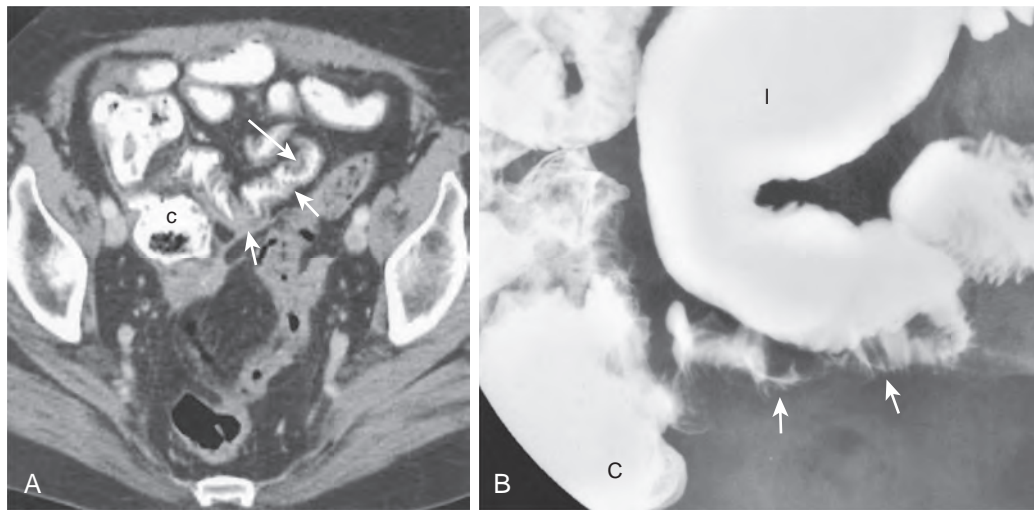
Radiation enteropathy causing low-grade small bowel obstruction. A. Axial CT through pelvis shows angulation and wall-thickening (short arrows) of the terminal ileum. In some areas, a mural stratification pattern caused by submucosal edema is evident (long arrow). The cecum (c) is identified. B. Spot radiograph from a small bowel follow-through shows angulation of the terminal ileum and smooth thick folds (arrows). The ileum (i) proximal to the radiation change is dilated. .
